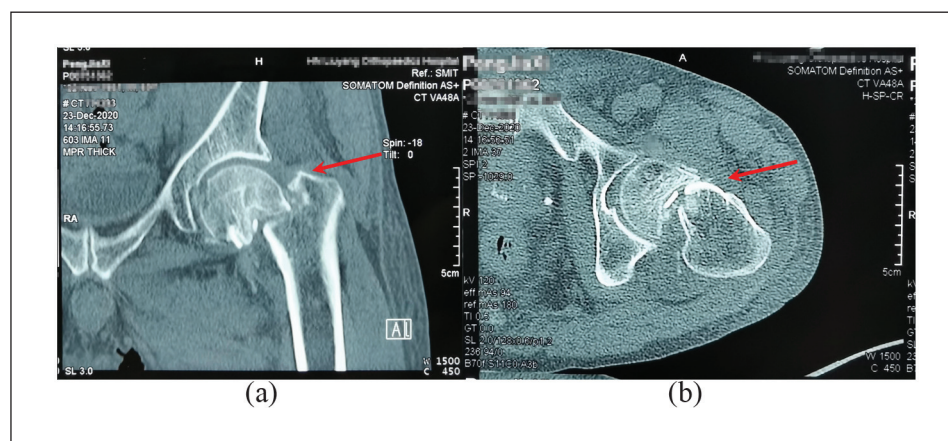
CT scan of the hip on 23 December 2020, showing left femoral neck fracture with marked displacement (red arrows).
